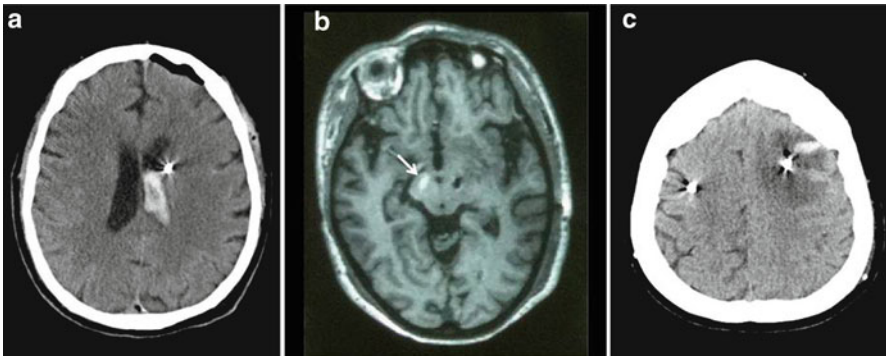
Images of hemorrhagic complications. (a) A computed tomography (CT) scan shows left ventricular hemorrhage following the surgery. (b) A T1-weighted image performed on the postoperative day 1 shows the microbleeding in the subthalamic nucleus. (c) A CT scan image shows edematous lesion surrounding the left deep brain stimulation (DBS) lead with intracerebral hemorrhage
